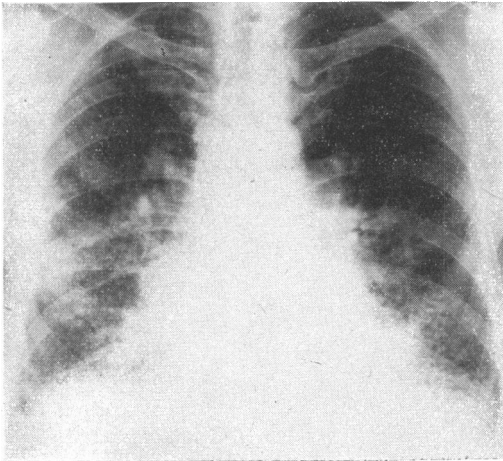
Case 3 *Radiograph of chest, December 1958, showing mottling throughout the right and in lower two-thirds of the left lung, with some 'honeycombing' at the bases*
